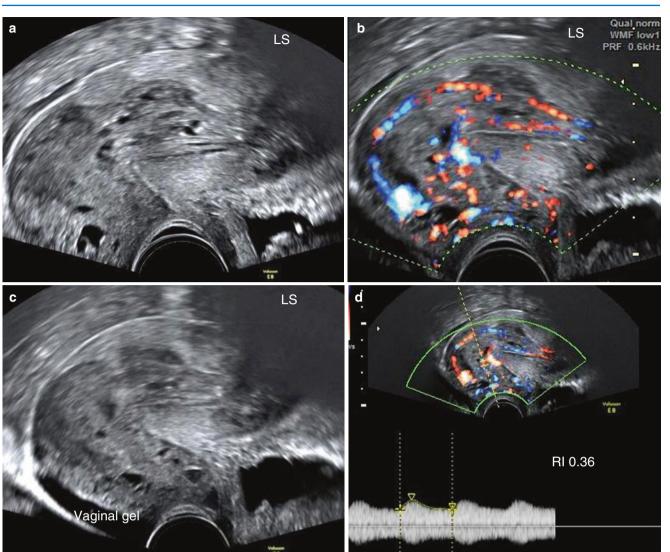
Endometrial polyp seen arising from the upper corpus of the uterus and presenting as a fleshy, large (42.7 cm^3) polyp with multiple cystic spaces protruding out of the cervix. The external os diameter was 1.8 cm. Polyp seen (a) on greyscale and (b) on Doppler. (c) Lower margins of the polyp are well seen on GSV. (d) The polyp shows high vascularity with low resistance flows. One of the causes for such flows (high colour score and low RI) can be superadded infection. *HPE:* endometrial polyp with cystic hyperplasia
